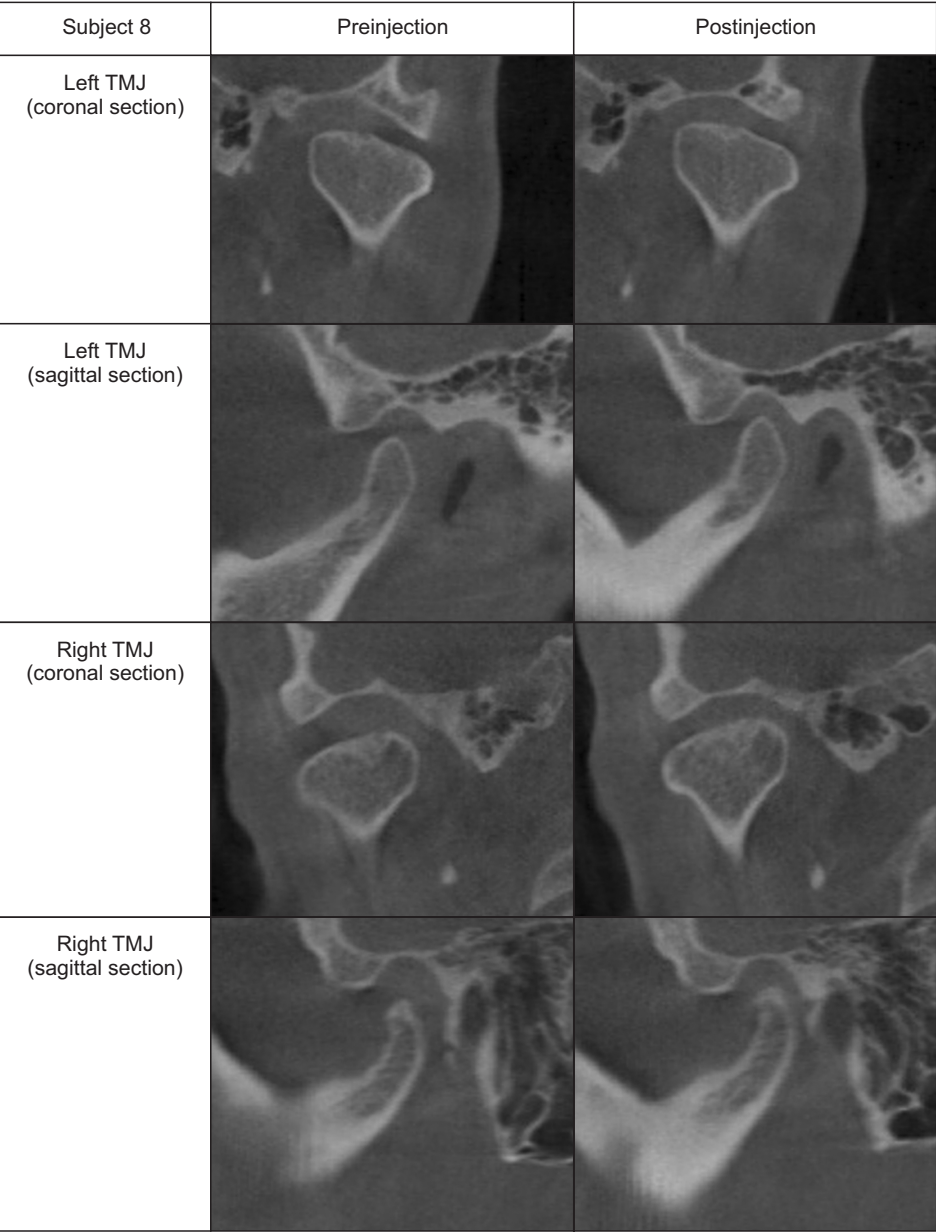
CBCT images obtained before and 6 months after bilateral BoNT injections into the masseter muscles in subject 8. CBCT, cone-beam computed tomography; BoNT, botulinum toxin; TMJ, temporomandibular joint.
